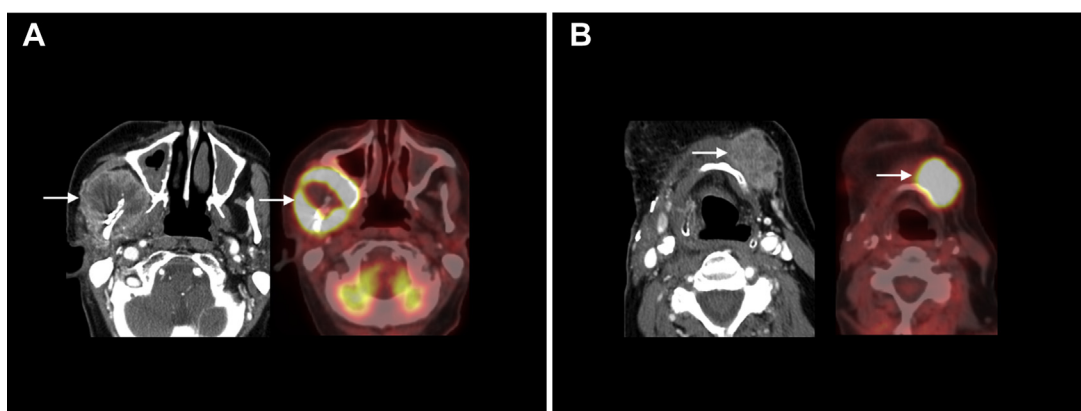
Neck Imaging Reporting and Data Systems (NI-RADS) primary and neck 4: T4a retromolar trigone SCCA s/p resection and flap reconstruction at outside hospital. (A) Twelve-week posttreatment baseline surveillance PET/CECT shows a huge heterogeneous mass at superior margin of the flap in the masticator space (arrow), with corresponding intense FDG uptake (arrow). (B) Inferiorly, there was an additional heterogeneous mass with intense FDG uptake anterior to the hyoid (arrows). These findings were compatible with multifocal recurrence. CECT = contrast-enhanced CT; CRT = chemoradiotherapy; FDG = fluorine-18-2-fluoro-2-deoxy-D glucose; FNA = fine needle aspiration; NI-RADS = Neck Imaging Reporting and Data Systems; SCCA = squamous cell carcinoma; s/p = status post.
